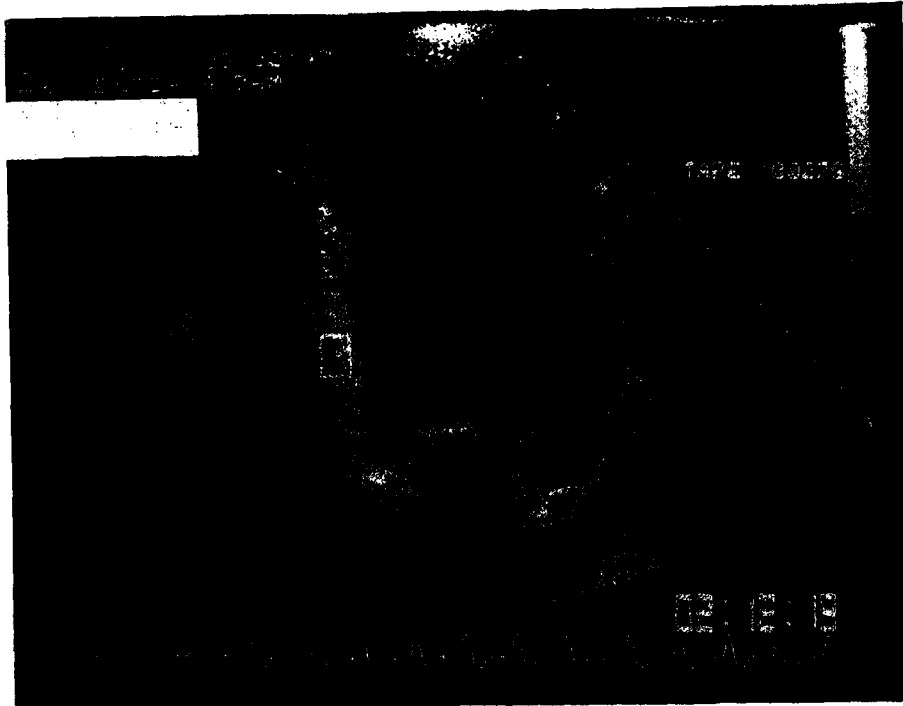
MC-2DE from apical four-chamber view. Region of interest at septal level is indicated by the square. This procedure is repeated for six end-diastolic frames before injection and for 25 frames during and after injection. For further explanation see text.
